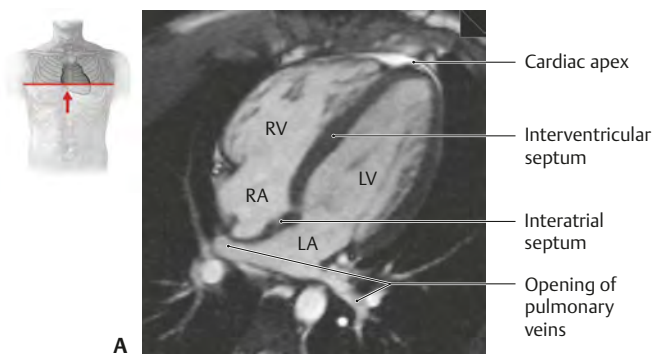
Transverse section through heart and similar MRI
